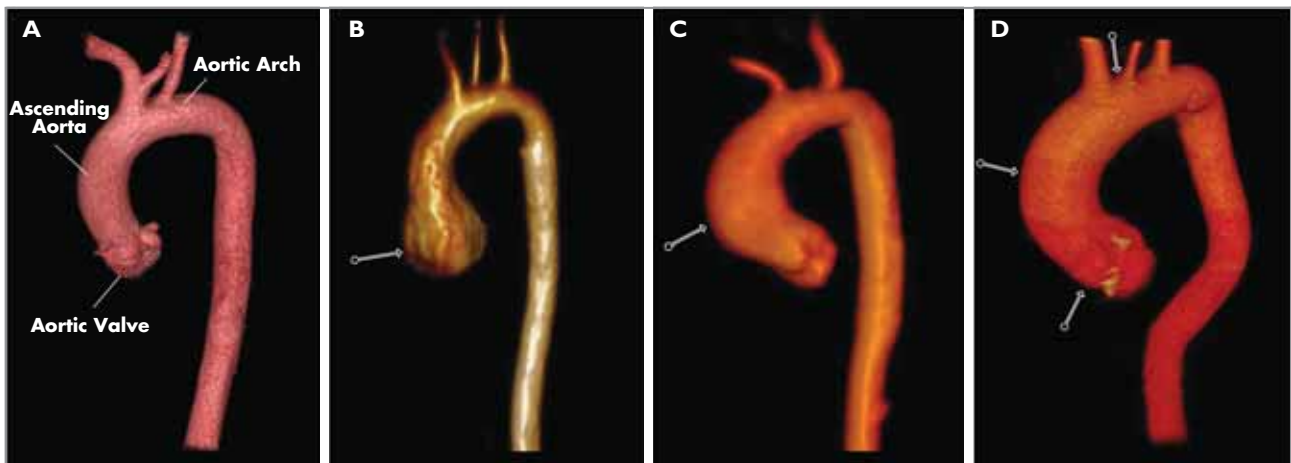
Aortic dilation associated with bicuspid aortic valve disease. A. Computed tomography angiography (CTA) of normal aorta. B. Magnetic resonance angiography (MRA) of isolated dilation of aortic sinuses. C. MRA showing aorta with dilation limited to the proximal ascending portion. D. CTA of an aorta that is dilated through the aortic arch.
